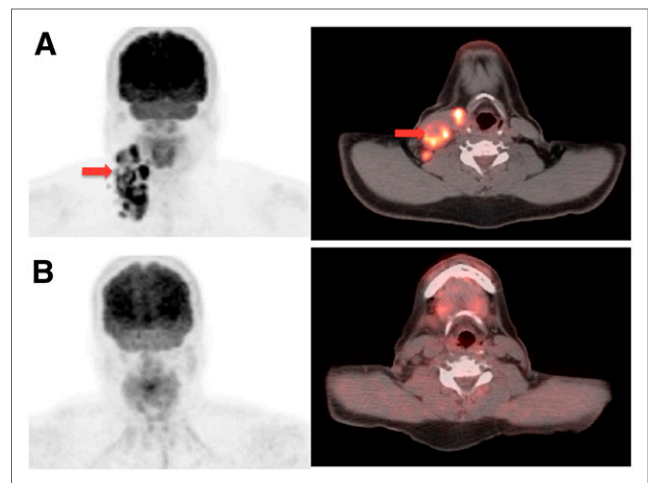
Negative PET/CT scan at 6–12 mo of follow-up. A 43-y-old man had TXN3M0 squamous cell carcinoma on right side of neck (arrows) that was strongly positive for p16 but HPV-16 negative. (A) Staging PET/CT did not identify primary site. Patient completed concurrent chemoradiation. He initially received cisplatin, docetaxel, and 5-fluorouracil with induction chemotherapy but had significant nausea, vomiting, and dehydration. He was then switched to carboplatin and 5-fluorouracil, which was dose-reduced to 650 mg/m². (B) Follow-up PET/CT scan obtained using same views at 7 mo after therapy showed no evidence of recurrence.
